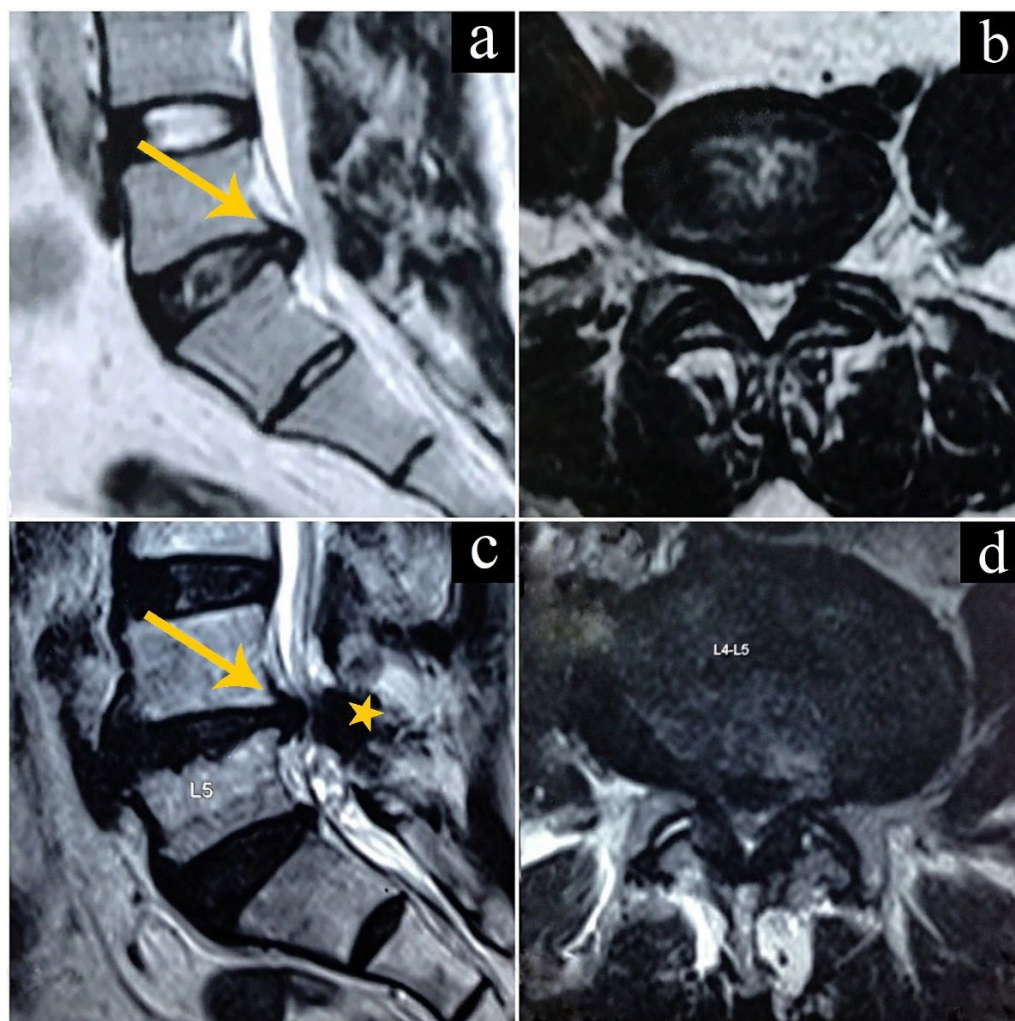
MRI images showing intervertebral disc herniations. (a) Sagittal view showing L5-S1 disc herniation (arrow), (b) corresponding axial view, (c) Sagittal view showing front and back compression due to herniating L4-L5 disc (arrow) and a thick buckled ligamentum flavum (star), (d) corresponding axial view showing circumferential compression.
